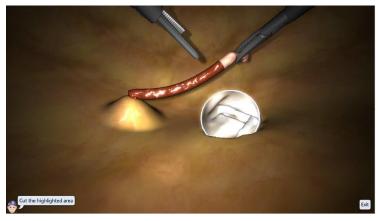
The Cutting Task. The left instrument are ultrasonic scissors, the right one is a grasper. An endoscopic bag is provided for deposit of the excised tissue. The elongated vessel features differently colored areas to mark cutting spots.
